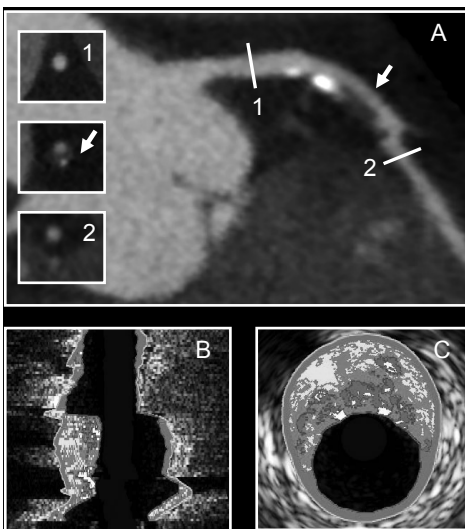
An example of a lesion with positive remodeling on 320-row CTA and corresponding findings on VH IVUS. (A) Curved multiplanar reconstruction of the left anterior descending coronary artery showing a large plaque in the proximal segment of the vessel. The diameter of the vessel at the plaque site is larger as compared to the diameter at the reference sections (1,2), indicating the presence of positive remodeling. (B and C) Corresponding longitudinal (B) and cross-sectional (C) VH IVUS images demonstrate indeed an outward-remodeled lesion, with a large plaqueburden (69%) and a large amount of necrotic core (19%), labeled in red, corresponding to a TCFA lesion.
